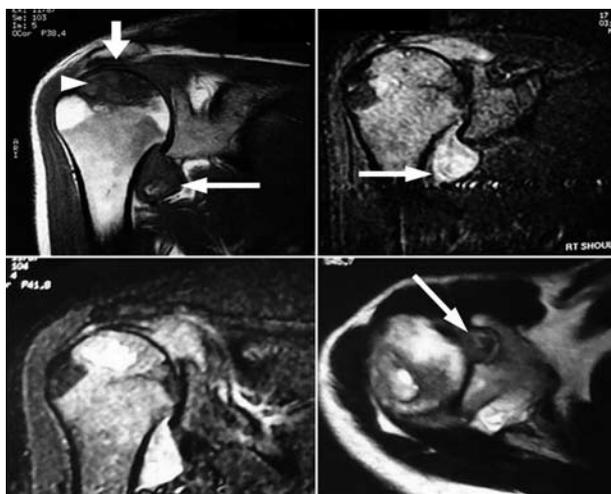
Magnetic resonance imaging showing area of altered signal intensity involving superior part of head of humerus (arrowhead), synovial effusion of shoulder joint (thin arrows) and reduction of acromiohumeral distance (thick arrow).
